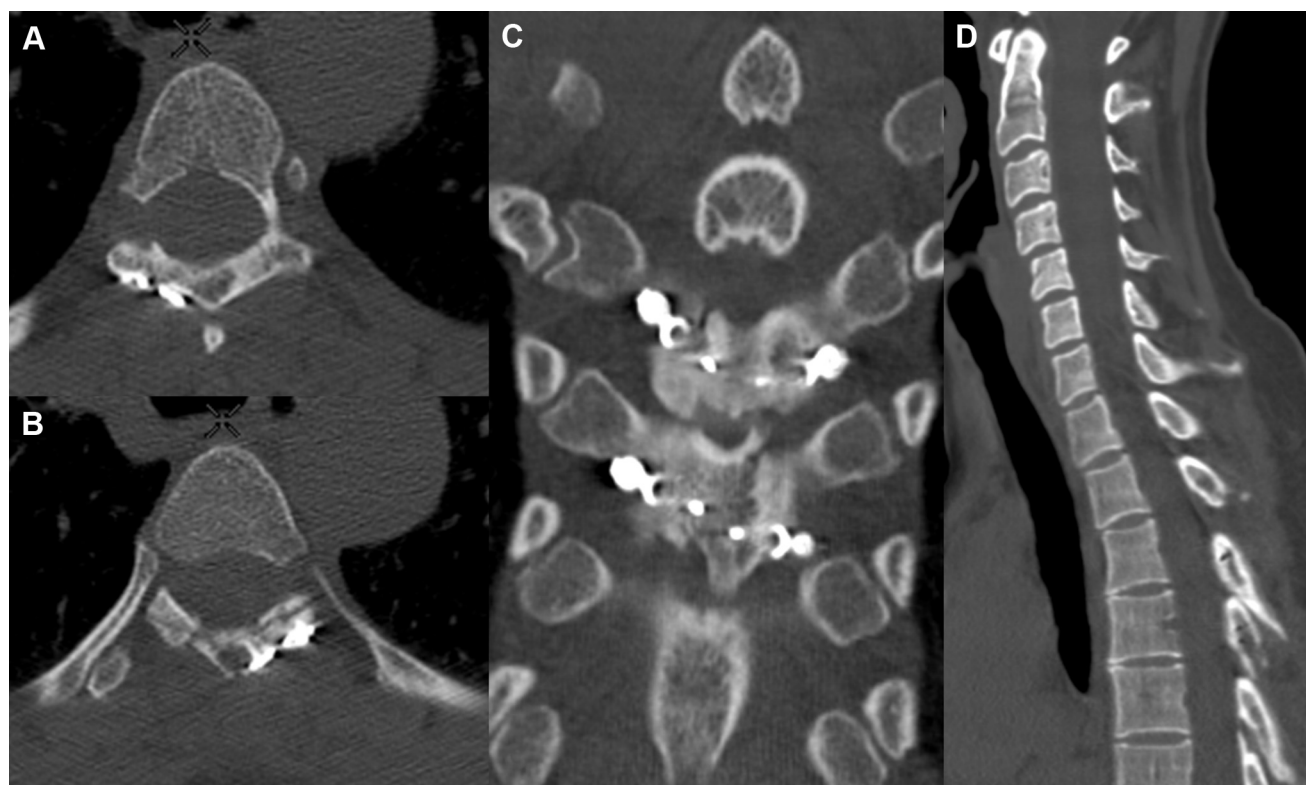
(A and B) Axial, (C) coronal, and (D) sagittal reconstructed computed tomography images obtained at 1-year follow-up document ossification of the laminoplasty plateau and maintenance of a correct spinal alignment.
